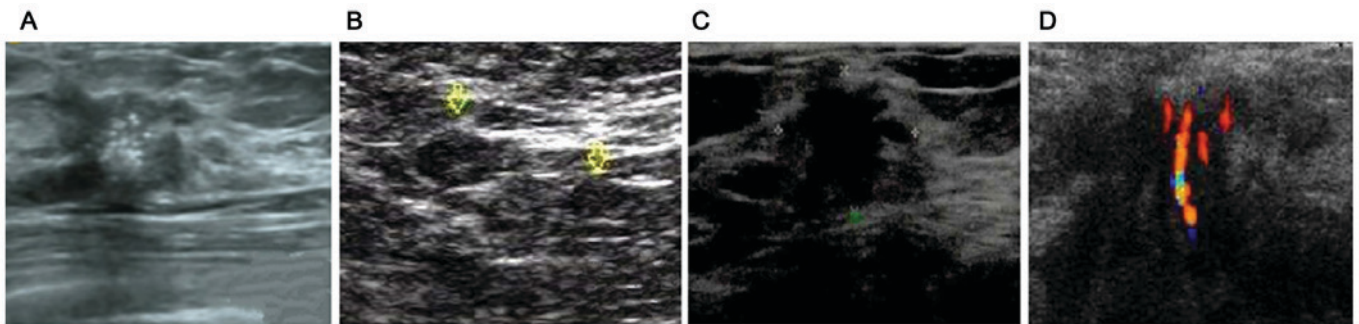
Typical ultrasound image in breast cancer. (A) Calcification sign. (B) Lymphatic metastasis sign. (C) Burr sign. (D) Abnormal vascular sign.
